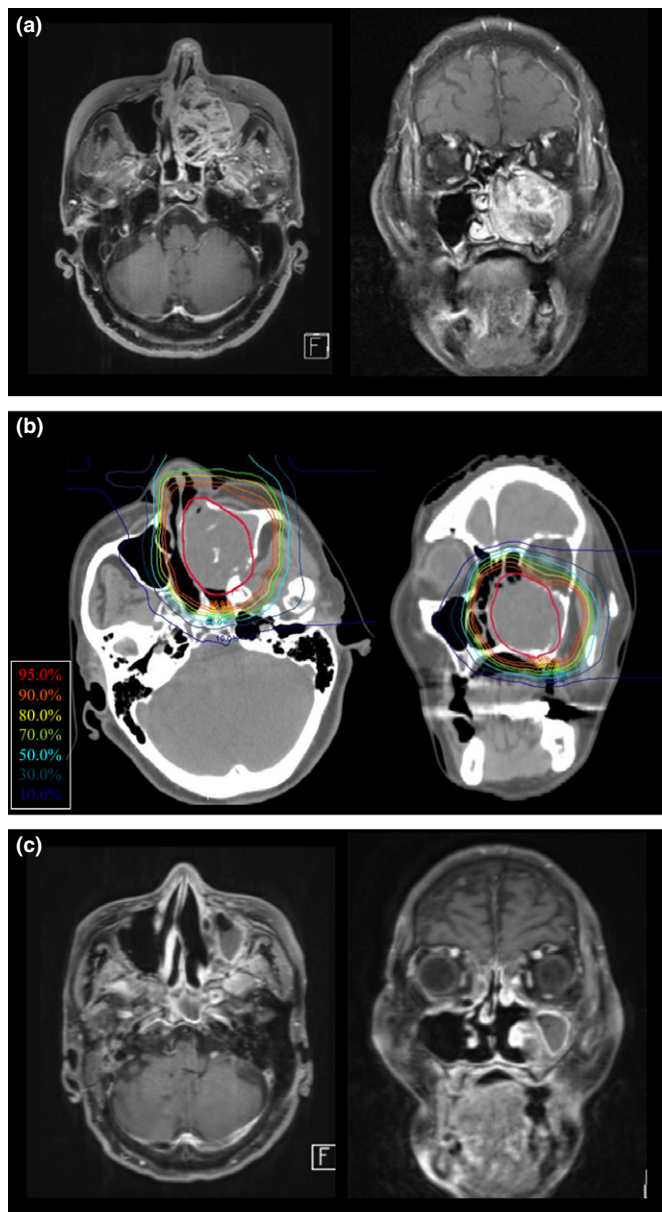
Representative case of nasal cavity adenoid cystic carcinoma treated with carbon-ion radiotherapy. The 77-year-old female patient had a T4aN0M0 left maxillary sinus tumor. (a) MRI contrast-enhanced T1-weighted images revealed the maxillary sinus tumor with the extension to the nasal cavity. The patient refused surgery and hoped to receive carbon-ion radiotherapy. (b) Dose distribution of carbon-ion radiotherapy using 64.0 Gy (relative biological effectiveness) in 16 fractions. The gross tumor volume is shown in red. (c) Twenty-four months after treatment, the tumor had shrunk on MRI. There were no late adverse events of grade 2 or higher. The patient was alive at 3 years after treatment without disease progression.
